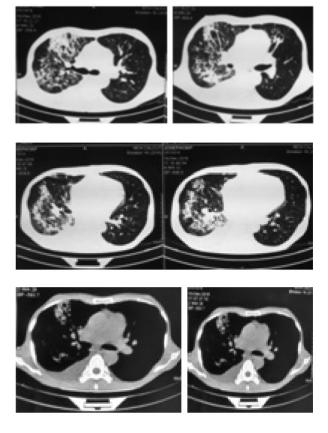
CT Thorax showing patchy consolidation with focal hyper attenuation and pleural effusion
